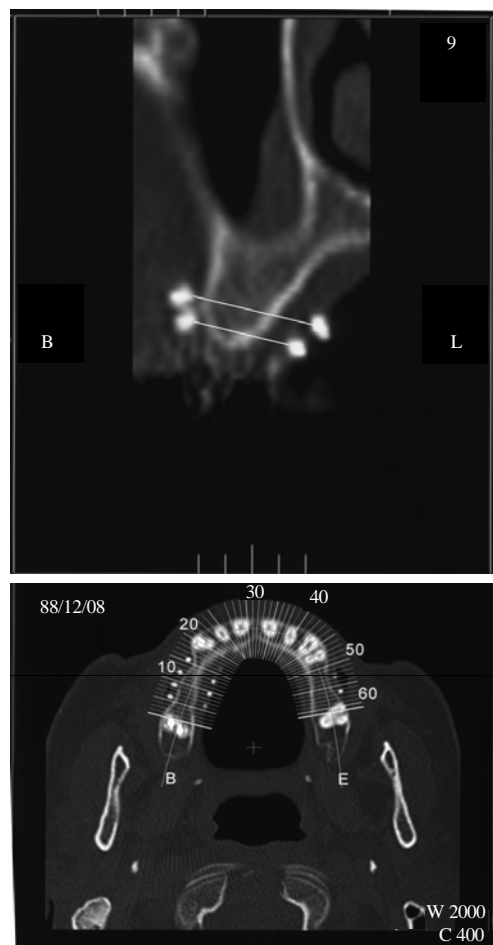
Spiral CT of maxilla with gutta-percha markers
